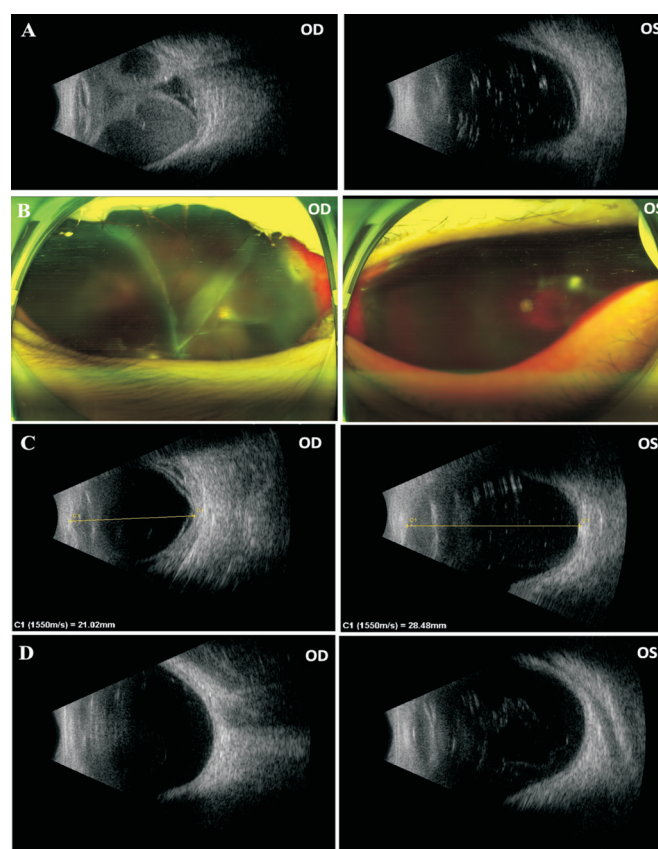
Ocular B-ultrasonography changes A: The next day of anti-glaucoma surgeries. Massive suprachoroidal expulsive hemorrhage was shown in the both eyes. B: Ocular B-ultrasonography showed aggravated suprachoroidal hemorrhage on the following day. C: Two days after r-tPA injection, the clots had fully liquefied in the right eye. There was no obvious clot liquefaction in the left eye. r-tPA: Recombinant tissue-type plasminogen activator.
